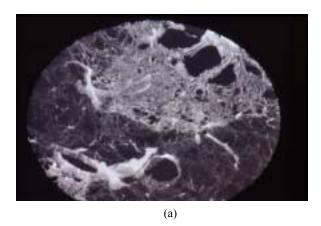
Micro CT images of the abnormal lung tissue (pulmonary adenocarcinoma in emphysematous lung) (a) Resolution: $24 \mu m$. (b) Resolution: $6 \mu m$.
